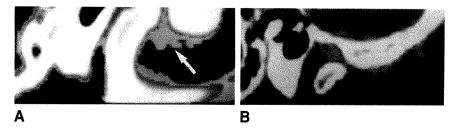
A, T1-weighted image in normal temporomandibular joint shows disk in normal position with some intermediate signal in posterior band (arrow).
